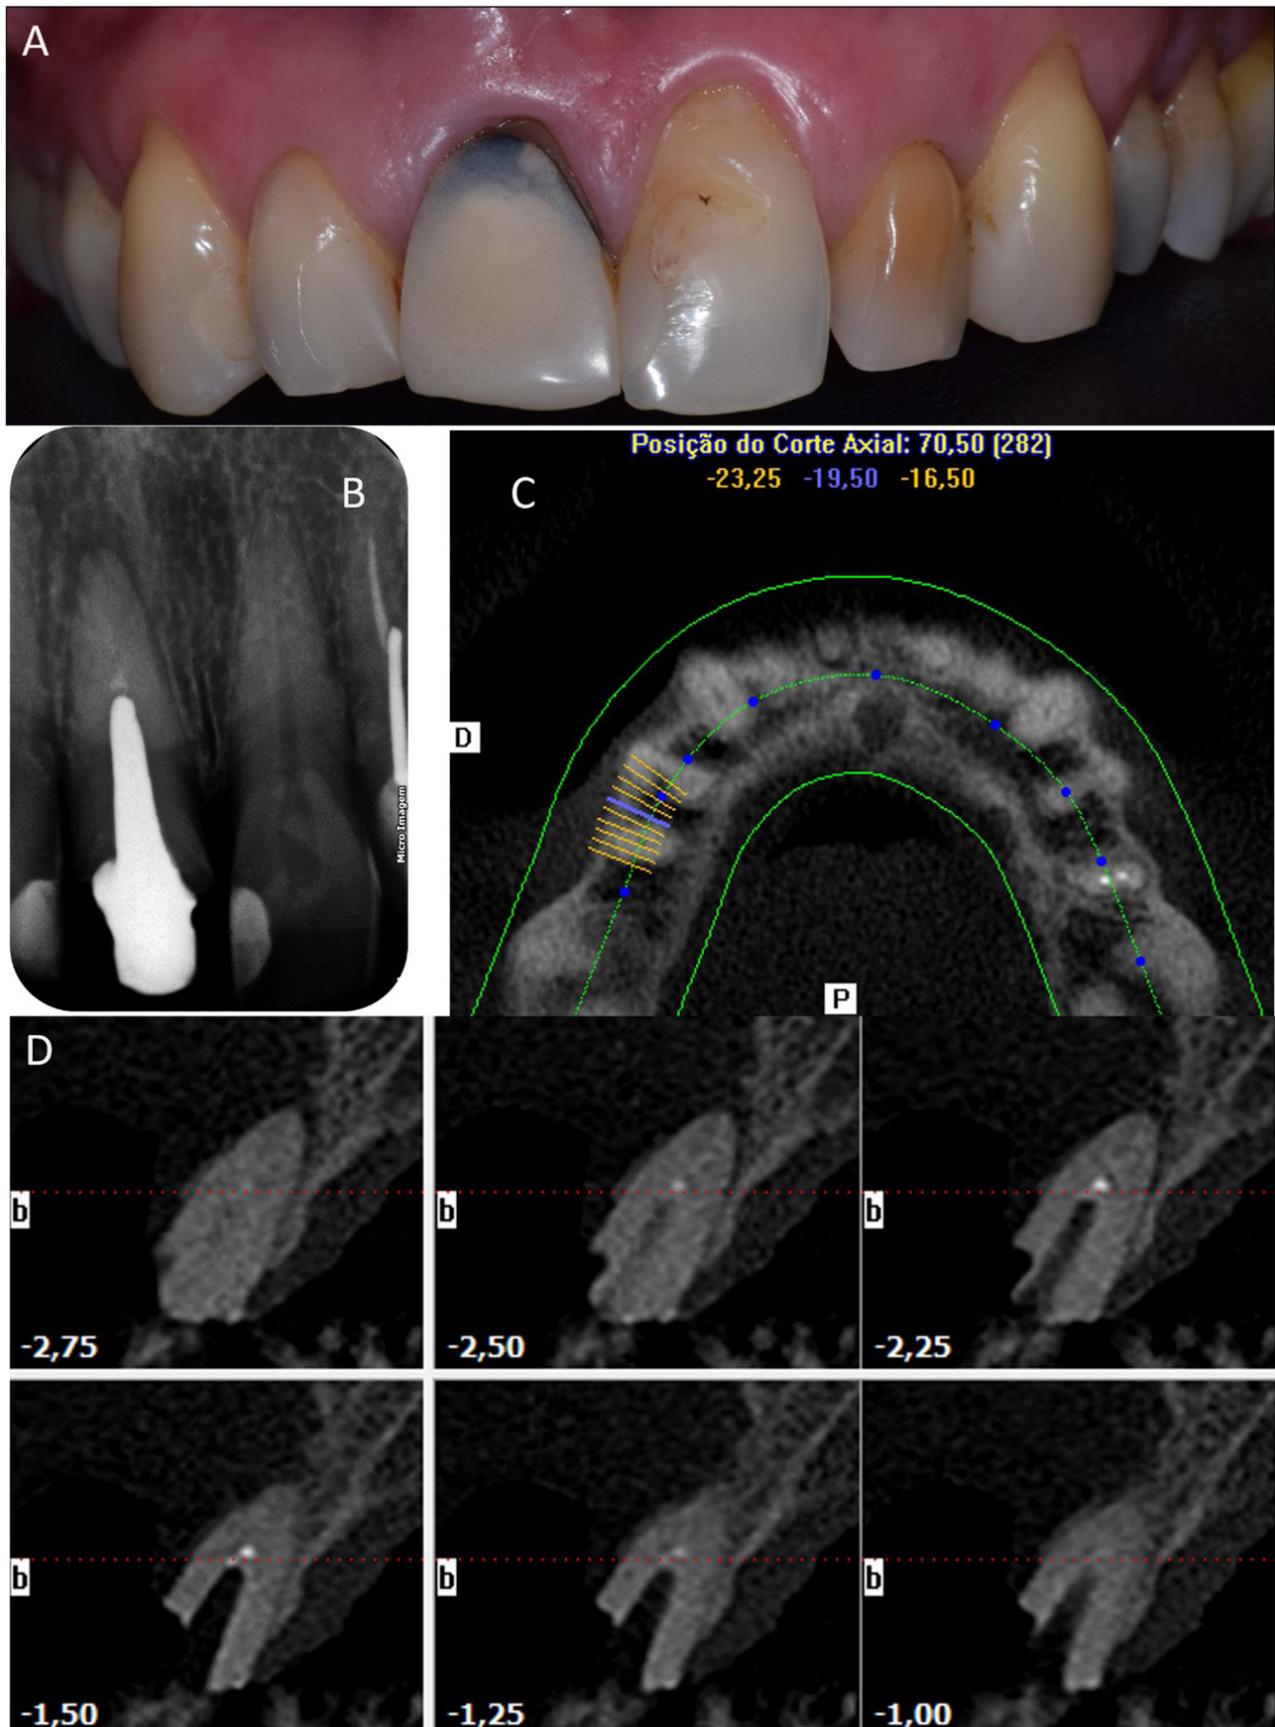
The clinical and radiographical examination of the calcified tooth. (A) Clinical intraoral image of the anterior teeth; (B) Initial periapical radiography of the tooth #11; (C) Cone-beam computed tomographic (CBCT) image of the sagittal section showing the relation of the lesion with the apex of the upper right central incisor; (D) axial reconstruction of the periapical lesion.
